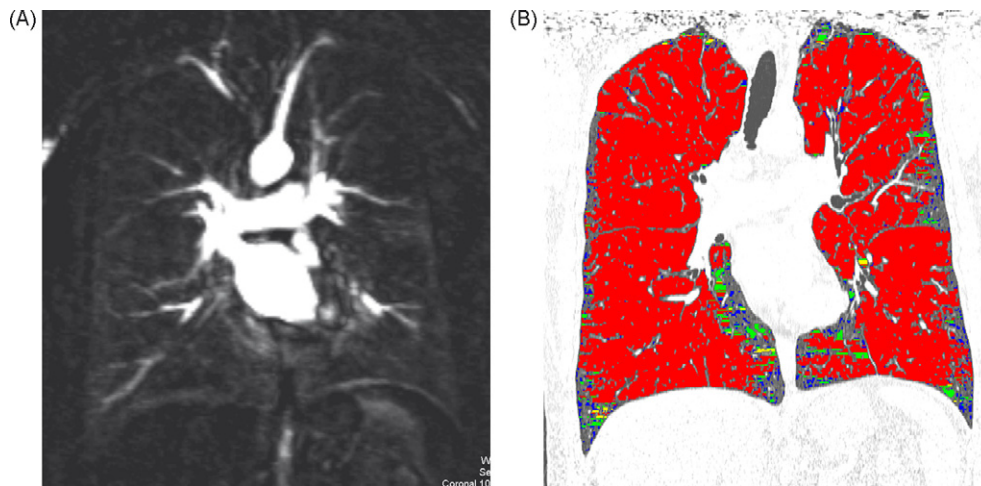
Fifty years old female patient suffering from emphysema GOLD class 3 (FEV_1 predicted 37%) with smoking history of 35 packyears. Ten millimeters MIP of original coronal lung perfusion MR images (A): the upper, middle and lower lobes on each side were scored 4. Color map of coronal CT image (B): clusters class 4 (red), class 3 (yellow), class 2 (green) and class 1 (blue). The upper, middle and lower lobes on each side were scored 4.
